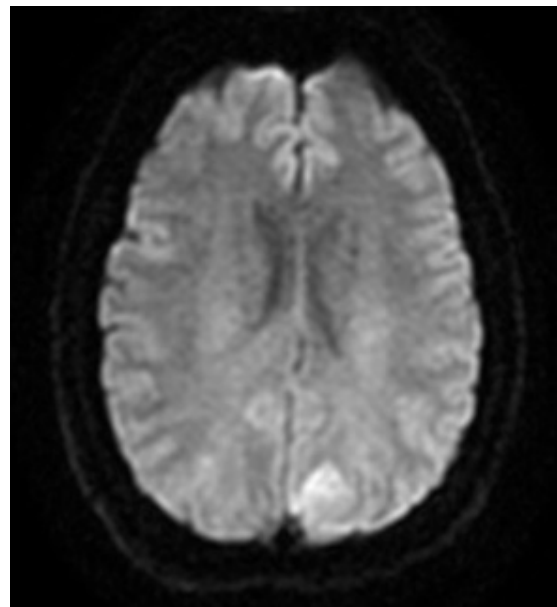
On the MRI of the brain with diffusion-weighted imaging (DWI) there is clear restricted diffusion.
